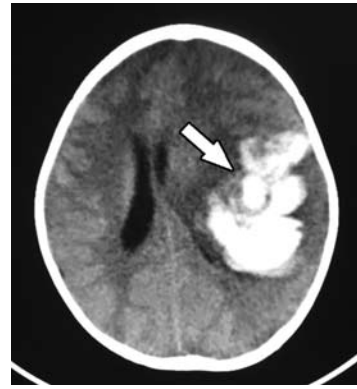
Initial CT scan demonstrating the large parenchymal hematoma in the left temporo-parietal region with significant surrounding edema and ischemic changes.
